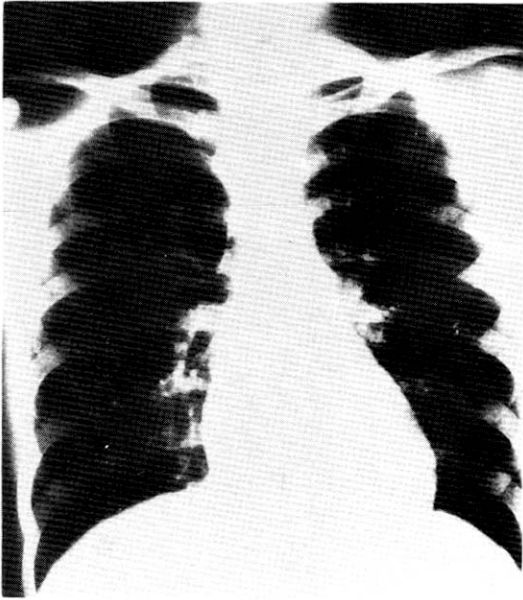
Roentgenogram of chest showing a normal heart size. No distinct poststenotic dilatation of the aorta is seen.
